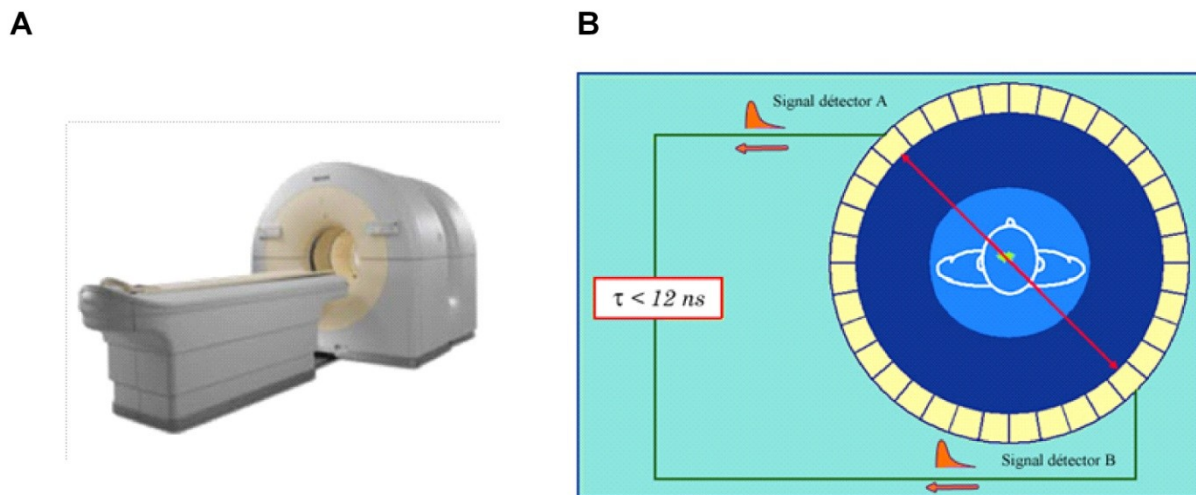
(A) Philips Gemini TF PET/CT scanner. CT and PET cameras can be seen in 1st and 2nd ring, respectively. Each ring offers an axial field of view for image acquisition of up to 18 cm. (B) Gamma photons emitted during positron annihilation are detected by scintillators, structured as a ring (figure from <http://www.laradioactive.com>).
